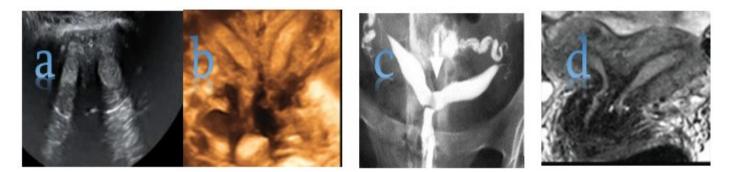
Bicornuate uterus with different imaging methods a. 2D ultrasound, b.3D ultrasound c.hysterosalpingography and d.MRI imaging
